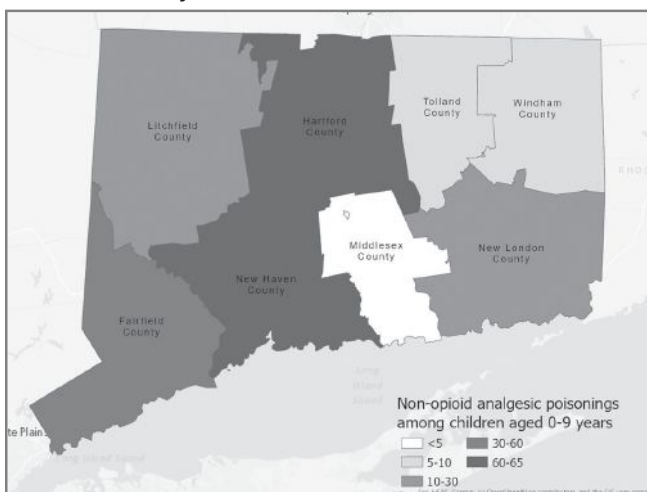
Frequency of nonopioid analgesic poisonings in CT residents aged 0–9 years treated in CT emergency departments, 2016–2018, county level.
